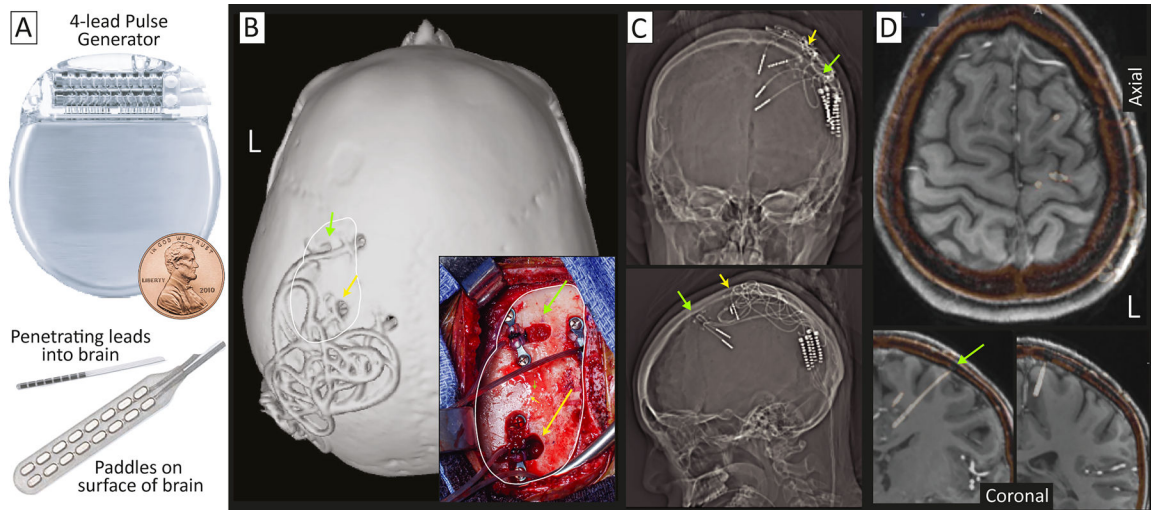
Constant subthreshold cortical stimulation (CSCS) of two spatially-separated SOZs. (A) Co-opted pulse generators typically used for DBS are used to deliver electrical current into the seizure network using paddle or penetrating lead electrodes. Target sites within the seizure network are initially identified with ECoG or SEEG. (B) An example implant with penetrating leads, seen on a skull surface rendering and intraoperative photograph (inset, with corresponding skull surface indicated by white trace). (C) AP and lateral x-rays showing penetrating leads. (D) Co-registered Implanted SEEG electrodes (white-orange) fused to the gadolinium-contrasted T1 MRI show implantation in the primary and pre-motor areas. Yellow and green indicate corresponding sites in (B-D).
